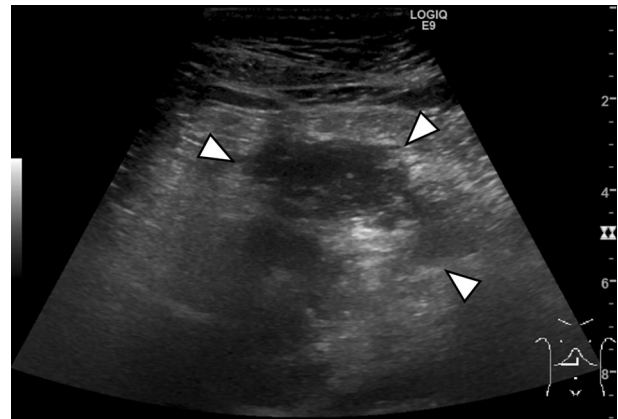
Extracorporeal sonographic image showing a mixed hypo- and hyper-echoic lesion around the head of the pancreas (white arrowheads). Parts of the border were indistinct
